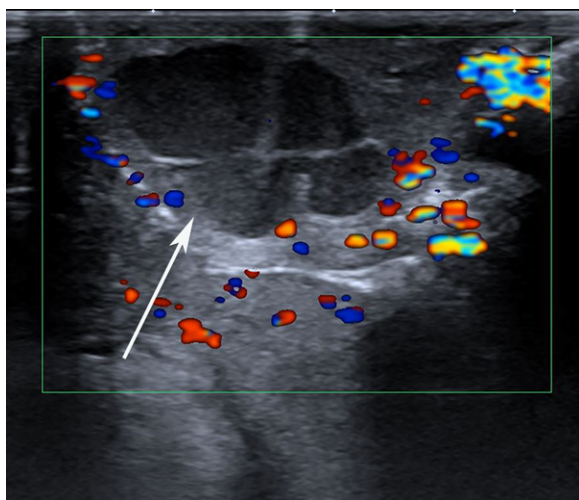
Incidental penile painless mass of a few years' duration in a 94-year-old man. Transverse color Doppler US image shows a multilocular cyst (arrow), with no internal color flow, within the right corpus cavernosum. The nature of the lesion was not confirmed because the patient declined intervention.
